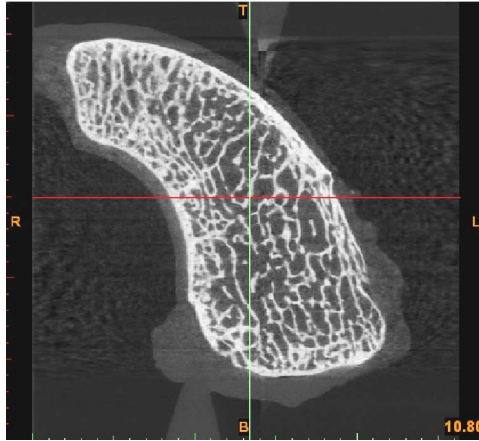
2D slice through a  $\mu$ CT-volume image of a scaphoid bone and articular cartilage. The imaged cartilage (bone tissue shown in white, cartilage in soft grey surrounding the bone outline) can be represented as a height-field on the supporting bony surface. The height-field is defined as a collection of base points on the bone surface, the bone surface normal at that point, and the height along the normal at which the normal intersects the cartilage external envelope.
